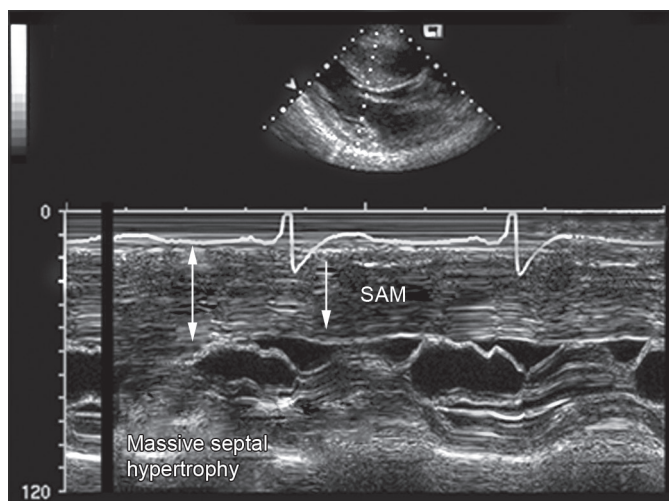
Echocardiogram in hypertrophic cardiomyopathy showing typical “systolic anterior motion of anterior mitral leaflet, severe left ventricular hypertrophy and narrow left ventricular outflow tract
